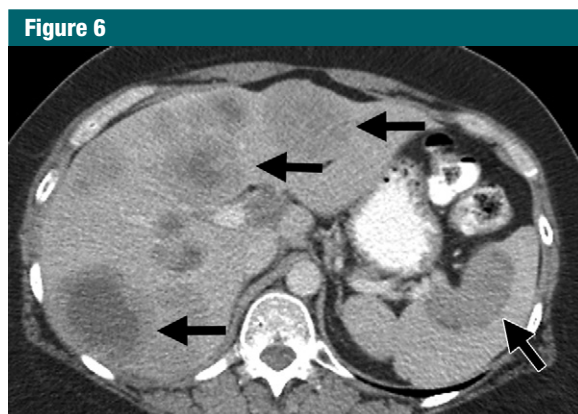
Axial contrast-enhanced CT scan in a 53-year-old patient with poorly differentiated serous adenocarcinoma demonstrates hematogenous hepatic and splenic metastases (arrows), with agreement between all reviewers.
